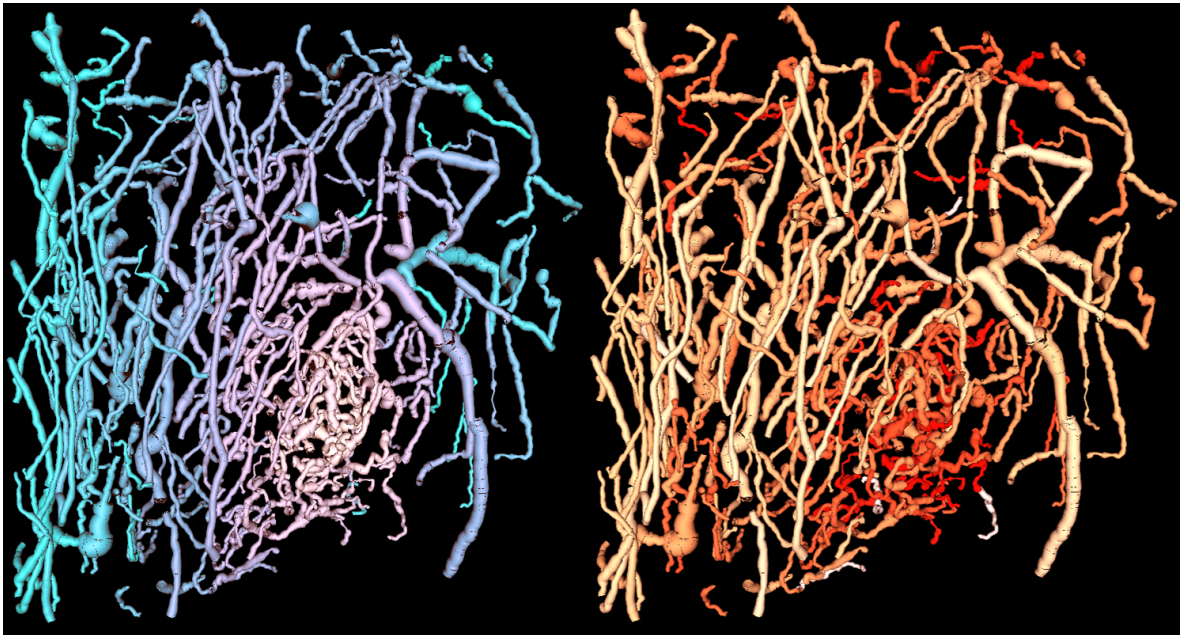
Segmented vessels are rendered and displayed in a color-map showing distance from the tumor margin (blue) and sum of angles tortuosity (red). The panel on the right is reprinted, with permission, from SR Rao\*, SE Shelton\*, PA Dayton. The fingerprint of cancer extends beyond solid tumor boundaries: assessment with a novel ultrasound imaging approach. *IEEE Transactions on Biomedical Engineering*, Vol. 63, No. 5, p. 1082-1086 (2016).
